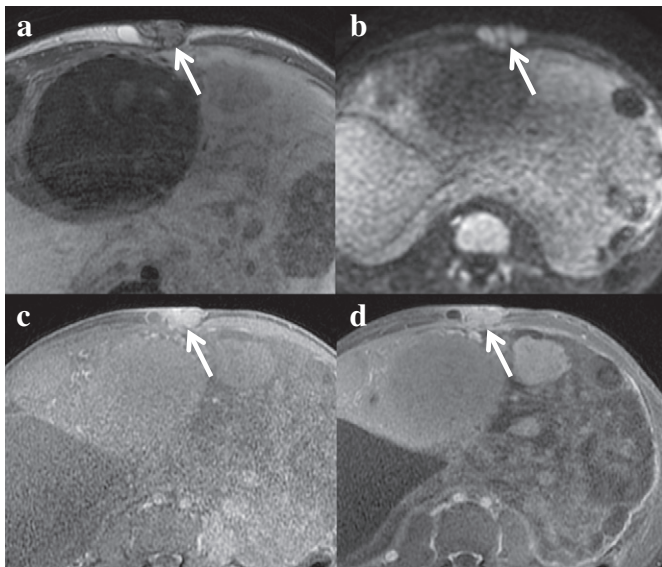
Axial magnetic resonance (MR) images. a) T2-weighted imaging. b) Diffusion-weighted imaging (b = 1000). c) Fat-suppressed T1-weighted imaging. d) Gadolinium-enhanced T1-weighted imaging. The umbilical tumor (arrow) shows low signal intensity on T2-weighted imaging and slightly high signal intensity on fat-suppressed T1-weighting images with small foci of slight signal hyperintensity on T2-weighted imaging, signal hyperintensity on diffusion-weighted imaging, and non-enhancement with contrast-enhanced MRI. MRI reveals multiple large different tumors in the uterine body comprising solid tumors regarded as typical leiomyoma, cystic tumors, and extensively degenerated tumors with cystic and edematous changes showing heterogeneous signal hyperintensity on T1- and T2-weighted imaging and poor enhancement.
